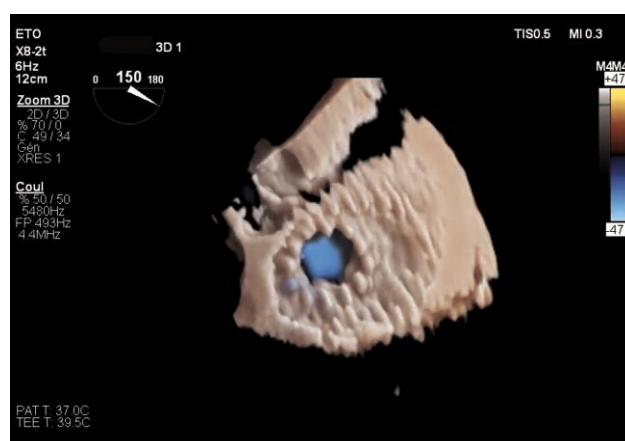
3D transoesophageal echocardiography view of the implant with colour.
